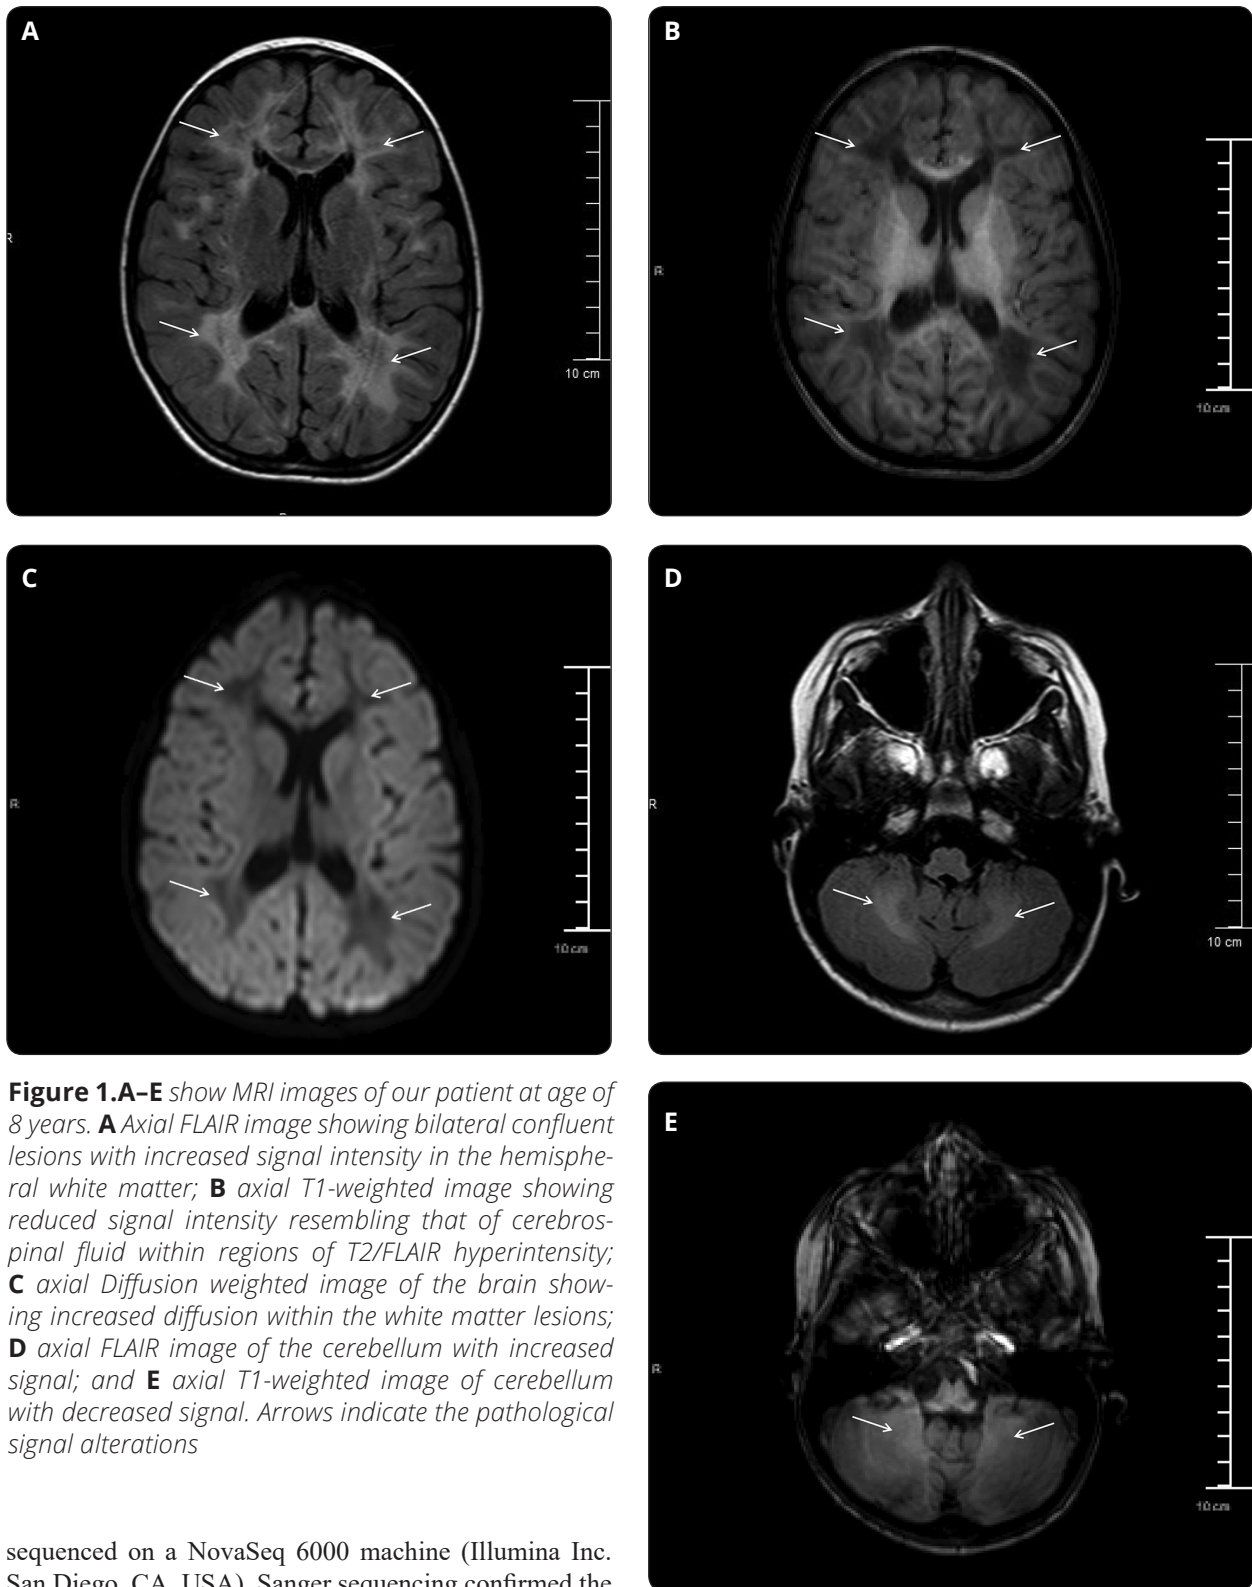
A–E show MRI images of our patient at age of 8 years. A Axial FLAIR image showing bilateral confluent lesions with increased signal intensity in the hemispherical white matter; B axial T1-weighted image showing reduced signal intensity resembling that of cerebrospinal fluid within regions of T2/FLAIR hyperintensity; C axial Diffusion weighted image of the brain showing increased diffusion within the white matter lesions; D axial FLAIR image of the cerebellum with increased signal; and E axial T1-weighted image of cerebellum with decreased signal. Arrows indicate the pathological signal alterations
